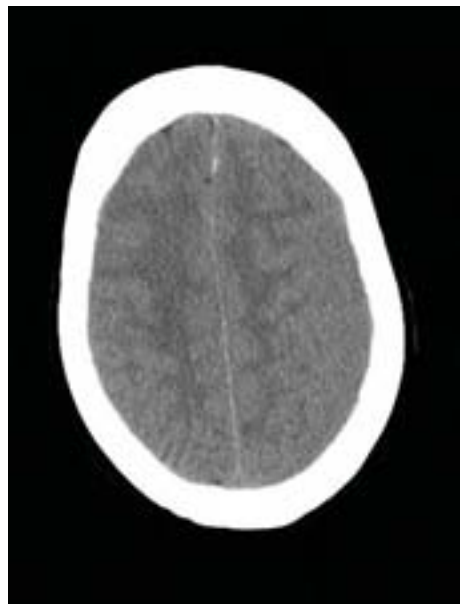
CT scan of a 62-year-old lady with leukemia and low platelets showing an isodense left sided chronic subdural haematoma. She presented with a history of headache. The density of the haematoma is the same as the adjacent cortical surface and can be easily missed.
